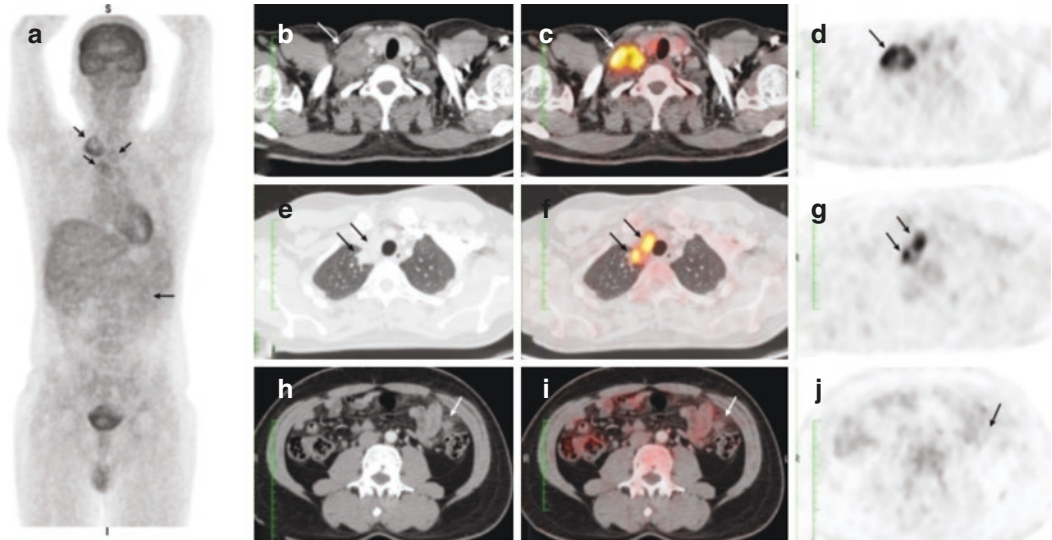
Disseminated tuberculosis. (a) Whole-body PET MIP image shows increased ^{18}F -FDG uptake in the right cervicothoracic region and superior mediastinum. Faintly increased ^{18}F -FDG uptake is seen in left hypochondrium. Corresponding (b–j) axial CT, fusion PET/CT, and axial PET images show increased tracer uptake in the conglomerate right supraclavicular lymphadenopathy (b–d), right
